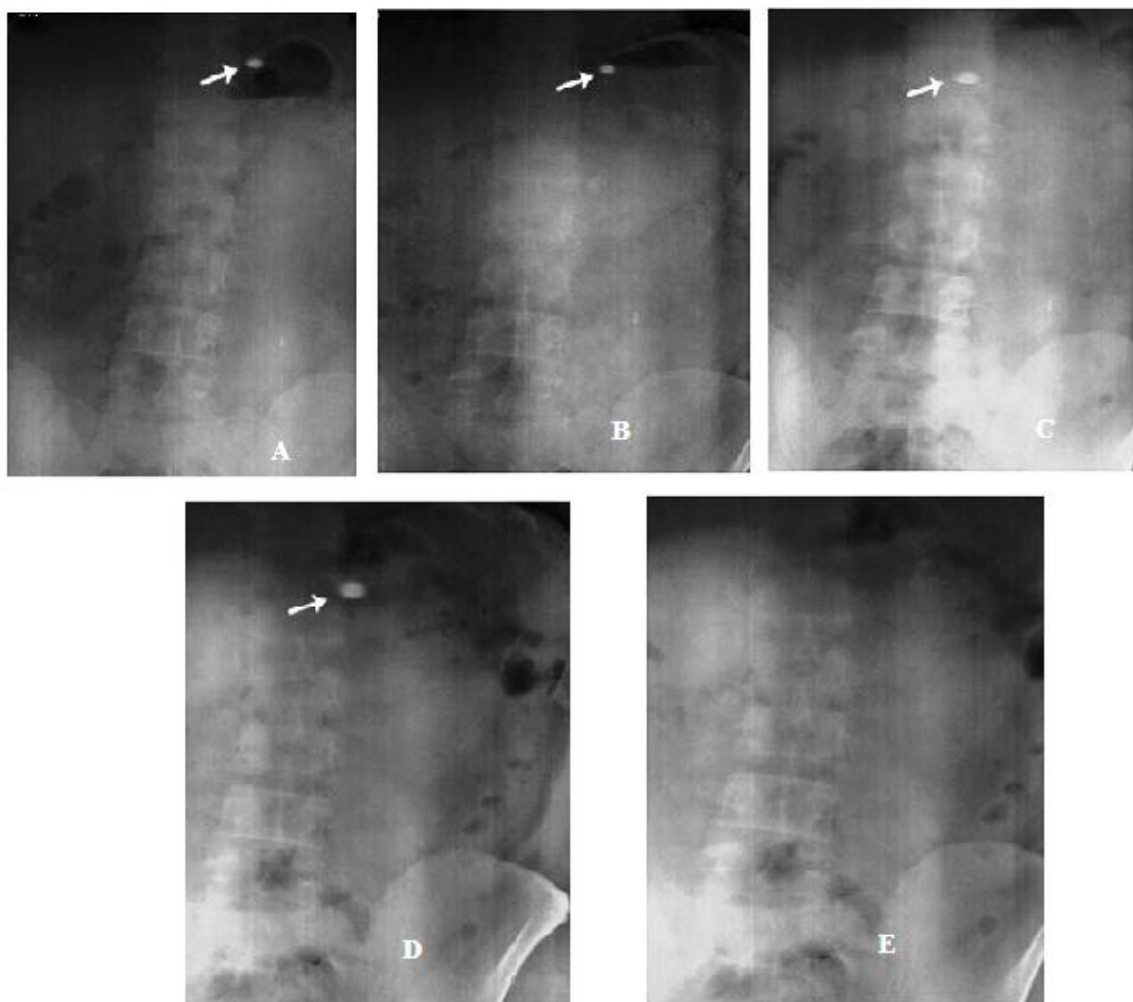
Radiographic images of optimized Cefixime floating tablet (F18) in the stomach at different time intervals
